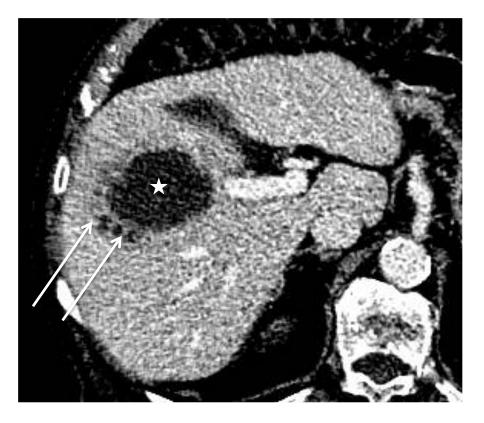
Escherichia Coli* abscess in an 89-year-old male patient. Axial portal-venous-phase computed tomography shows three small hypoattenuating areas (arrows) corresponding to the initial lesion, which coalesce to form the large cavity (star).
